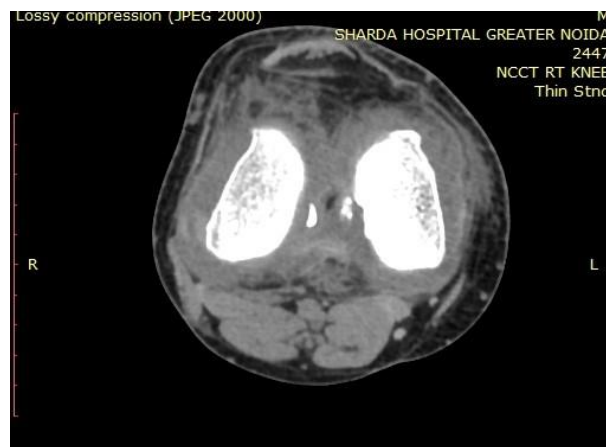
Axial CT image.
